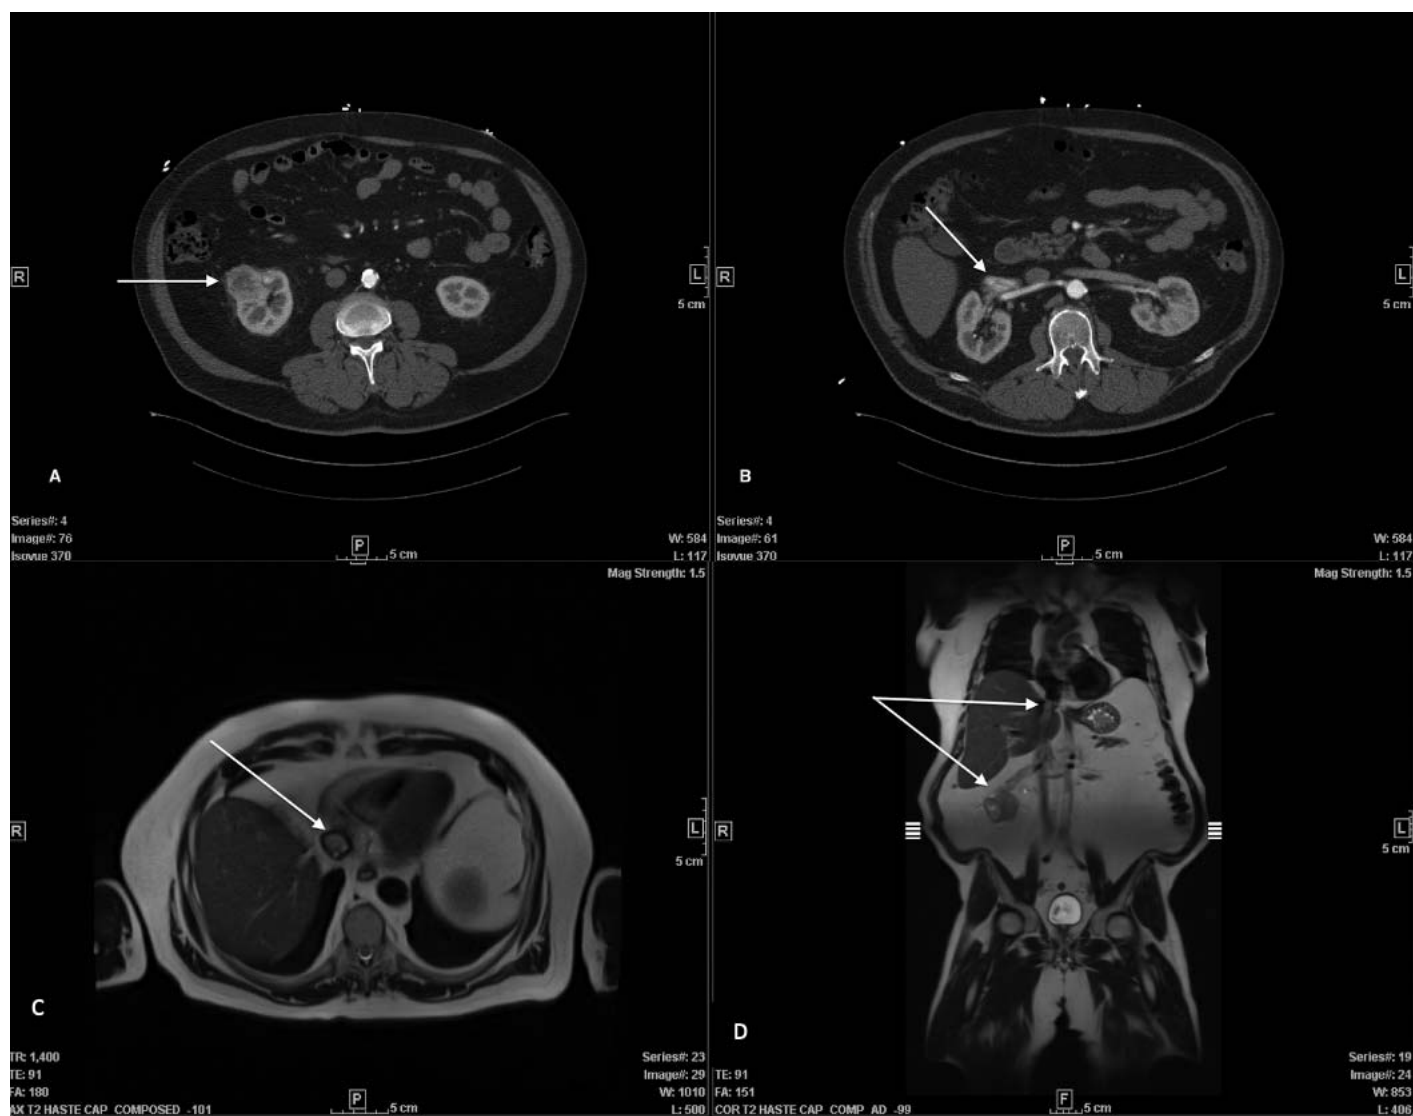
Imaging demonstrating evidence of RCC with tumor thrombus. (A) Contrast-enhanced CT with $4.3 \times 3.9 \times 3.7$ -cm mass in the right kidney (white arrow). (B) Contrast-enhanced CT demonstrating right renal vein defect (white arrow). (C) IVC filling defect of IVC on MRI (white arrow). (D) Coronal MRI exhibiting filling defect from lower cavoatrial junction to infrahepatic IVC, measuring approximately 5 cm in length craniocaudally (white arrows). CT, computed tomography; IVC, inferior vena cava; MRI, magnetic resonance imaging.
